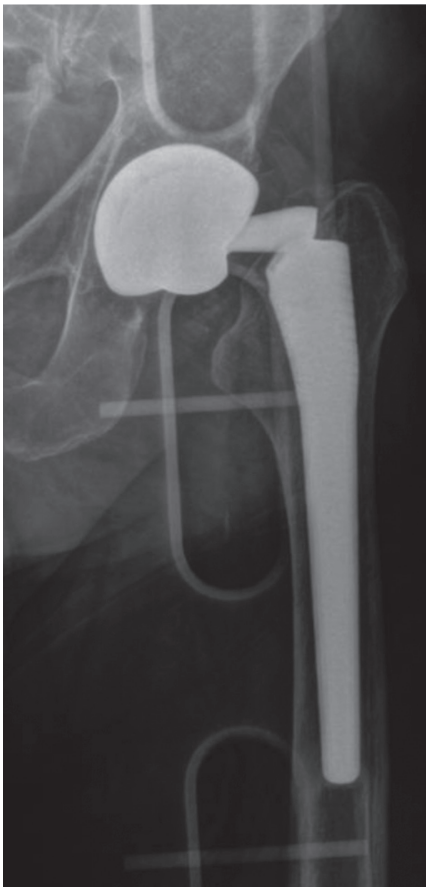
Case 2. Left hip AP view radiographs showing a complete fracture of the modular neck at the stem-neck junction
